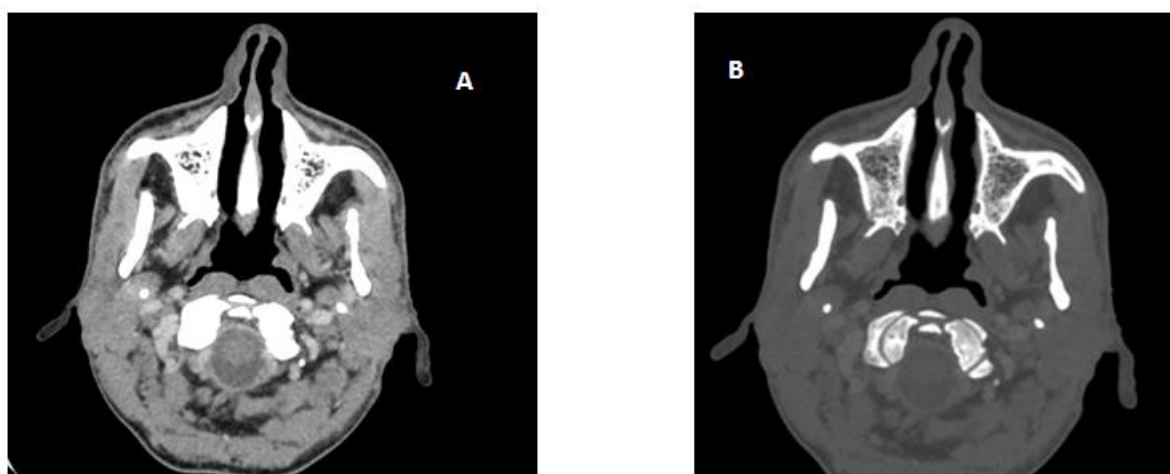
Contrast Enhanced CT scan showing obliterated maxillary sinus in A) soft tissue window, B) bone window
